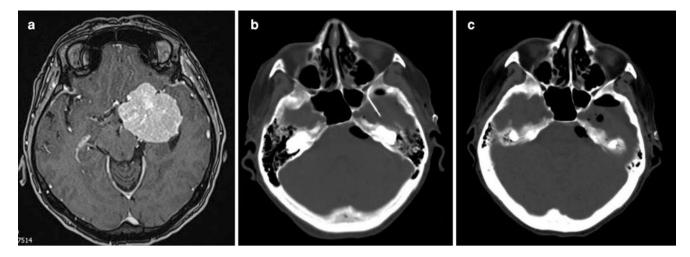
In a 64-year-old woman, surgical removal of a left-side anterior clinoid meningioma was complicated by retention of a cottonoid in the wound. Preoperative magnetic resonance imaging demonstrated a large tumor (a), and its resection was uncomplicated, but absence of one cottonoid was noted at the end of the surgery, and, despite thorough inspection of the surgical wound, it was not possible to disclose its location.
